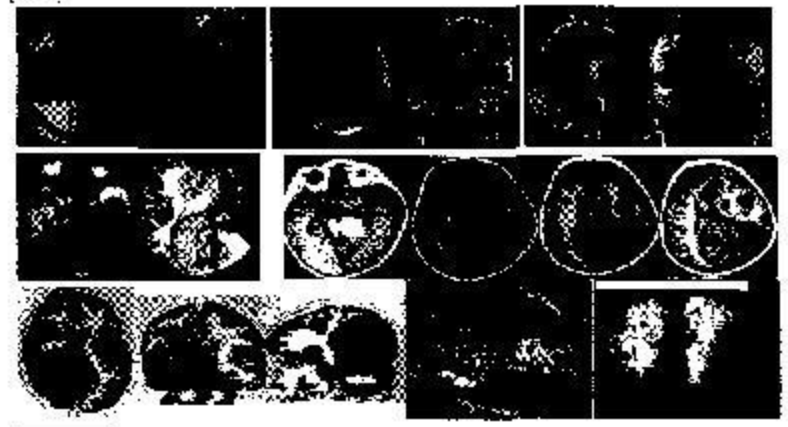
MRI scans showing bilateral perisylvian heterotopia in grey matter associated with corpus callosum partial agenesis and anomalies of the surrounding white matter in all cases.
